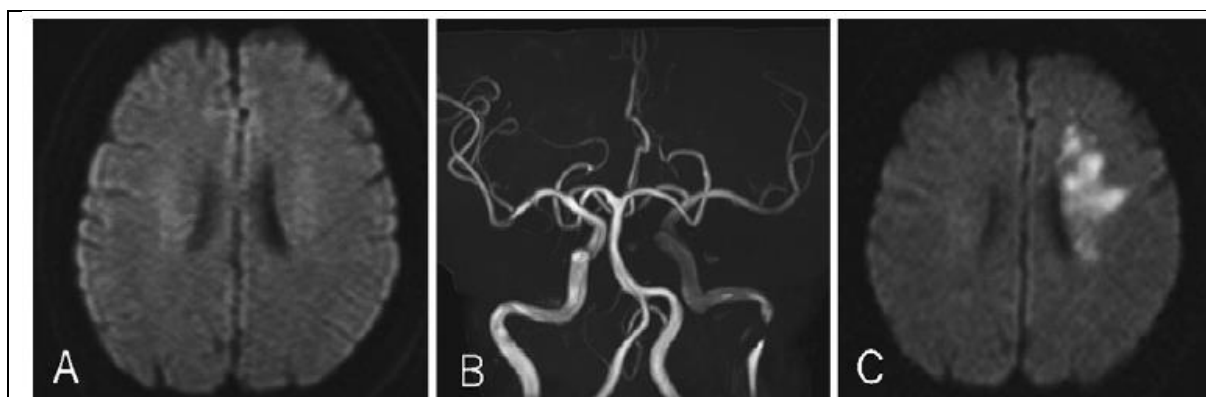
Initial findings before the first CAS treatment. Magnetic resonance imaging (MRI)-diffusion-weighted imaging (DWI) showed no cerebral infarction (A). Magnetic resonance angiography showed severe stenosis of the left internal carotid artery (B). MRI-DWI on the third day showed enlarged infarct centered on the watershed area
